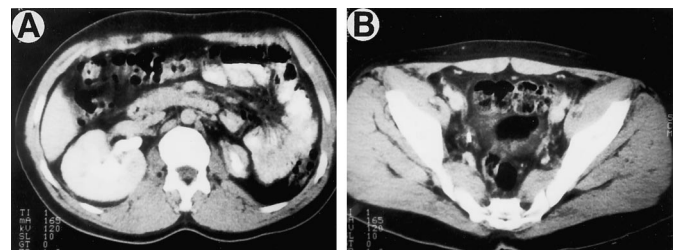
A, abdominal CT 4 months after catheter insertion reveals complete resolution of urinoma. B, pelvic scan also shows complete resolution.
